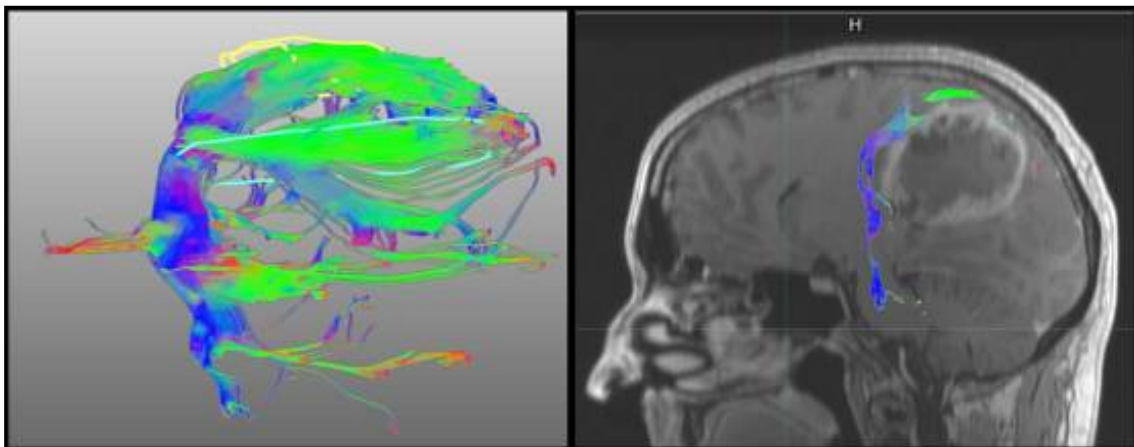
The left image shows DTI based fibertracking with a 3D reconstruction of an anteriorly displaced pyramidal tract. In the image on the right the calculated fiber tracts are shown after image fusion with anatomical data (T1 weighted contrast enhanced MRI). Here the anterior displacement of the pyramidal tract by the glioblastoma can be clearly recognized. Blue lines in the image represent fibers in cranial to caudal direction, green lines left to right and red lines fibers in anterior to posterior direction NeuroQLab 2.7 (Institute for Medical Image Computing, Fraunhofer MEVIS, Bremen)
